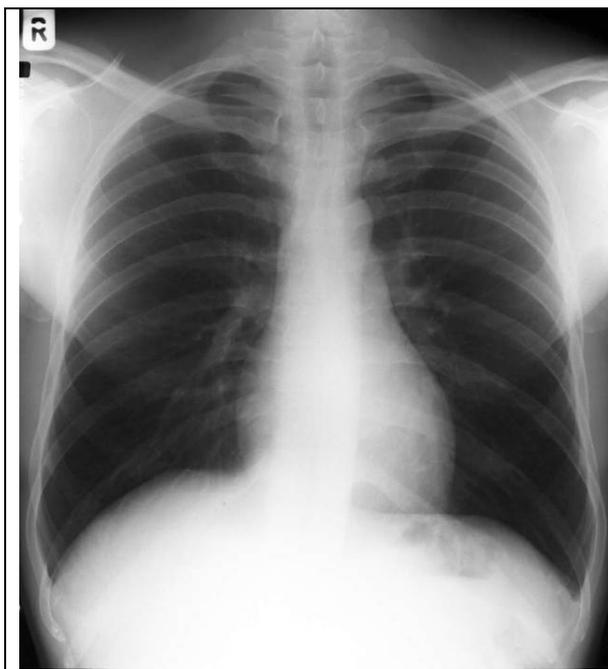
Chest radiograph in frontal projection.
